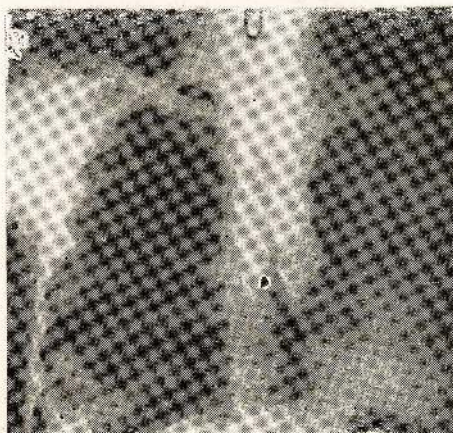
X-ray of chest after Ba-swallow showing a "destroyed lung" on the left and a carcinoma of the oesophagus.
